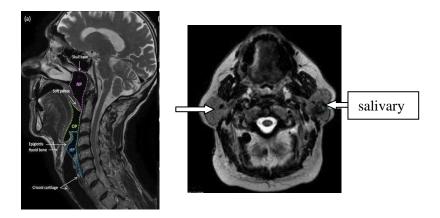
MR images of the head and neck region demonstrating the pharynx, larynx, nasal cavity, paranasal sinuses and the salivary glands (white arrows)
